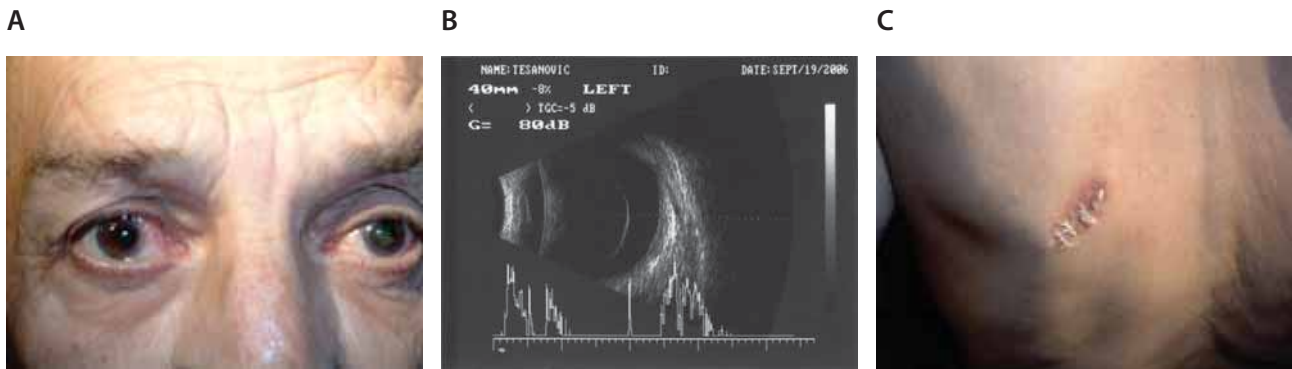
Iris metastases of the both eyes (A); Ultrasonography of the left eye (B); Subcutaneous metastases (C);
